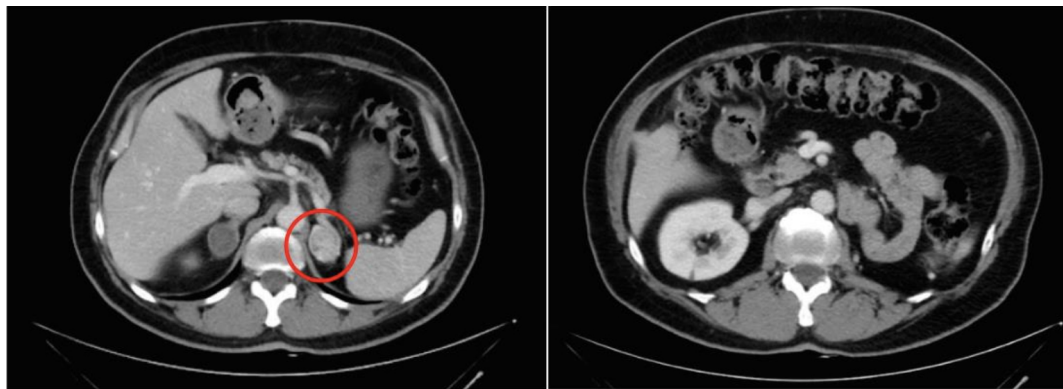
CT scan showing the adrenal solid expansive lesion (30 mm × 20 mm) mass and left empty renal lodge. CT: Computed tomography.
